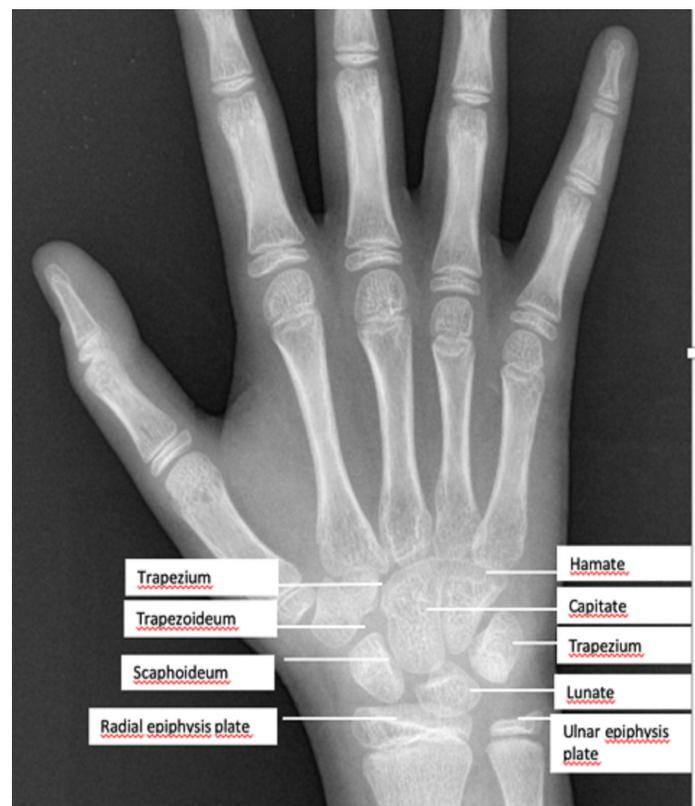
The maturation of the carpal bones, epiphyseal lines and the status of the styloid process used in the determination of bone age in the wrist radiography
